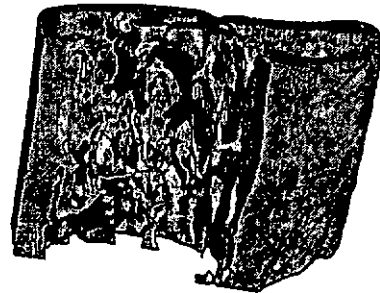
3D  $\mu$ CT reconstructions of cortical (left side) and trabecular (right side) structures. The trabecular structure shown was cut at the vertical mid-point of the cortical picture. (Resolution: 36 $\mu$ m)
